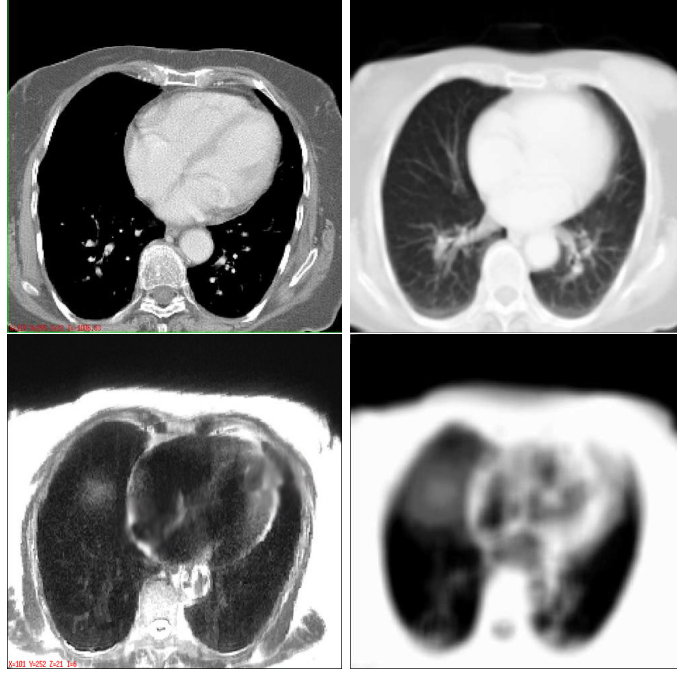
Top row: Sample thorax CT slice (left) and attenuation map obtained by scaling Hounsfield units to  $\mu$  values (right). Bottom row: Sample MR slice of same patient (left) and attenuation map generated by binary thresholding (right).
